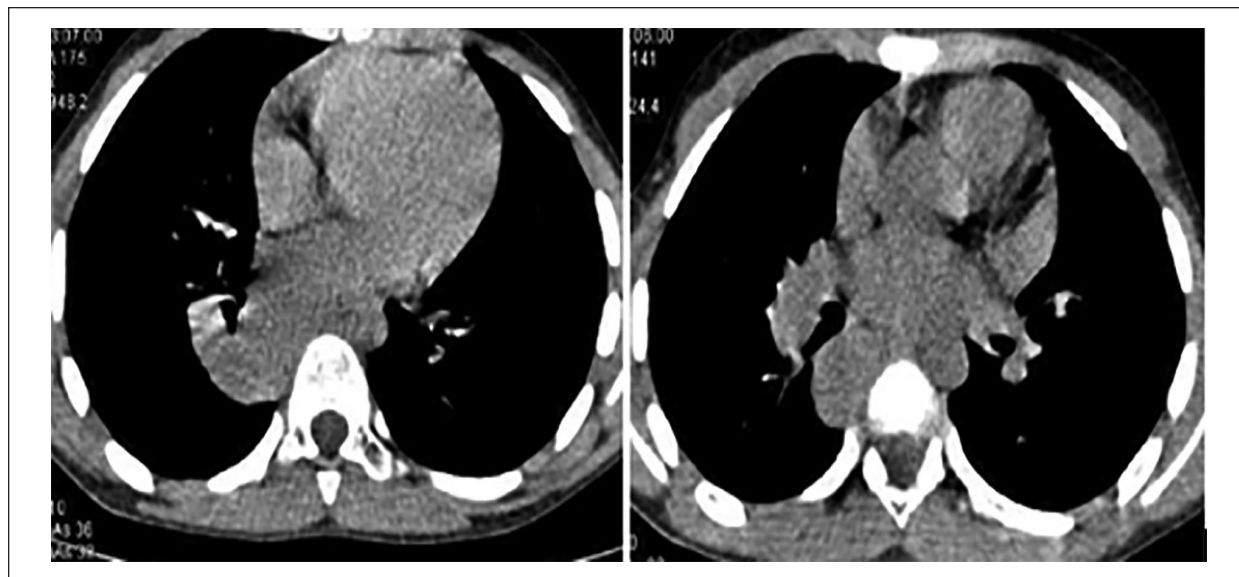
Axial CT without injection showing a large soft tissue oval, proximal as vascular nature in the postero-basal of the right upper lob.
